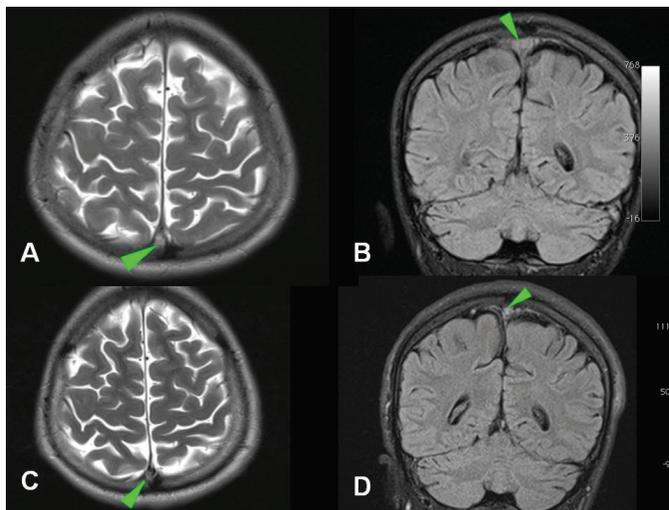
Magnetic resonance imaging before (A, B) and after (C, D) anti-TNF of a 21-year-old male patient with dural venous sinus thrombus diagnosed with Behçet's. Axial T2-weighted MR (A), and coronal FLAIR (B) images show thrombus in superior sagittal sinus (arrowhead). Axial T2-weighted MR (C), and coronal FLAIR (D) images show partial thrombus in superior sagittal sinus (arrowhead)
